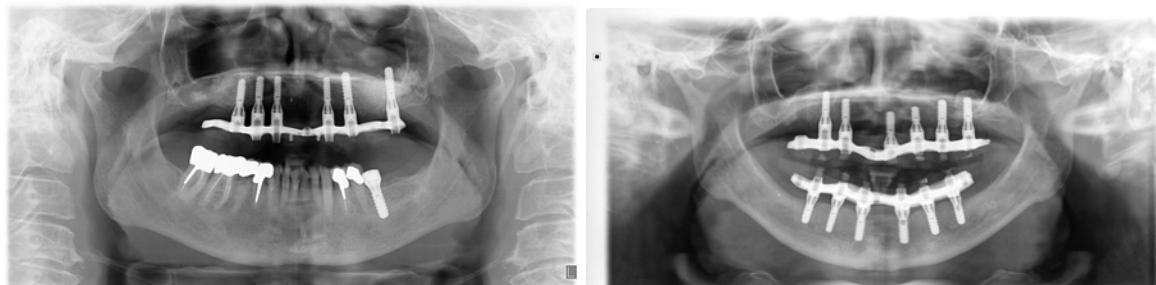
12 months post-op panoramic x-rays:
